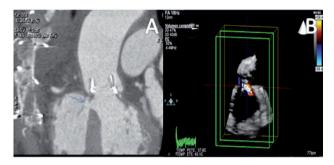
Computer tomography scan and 3D echocardiography images of the defect.
